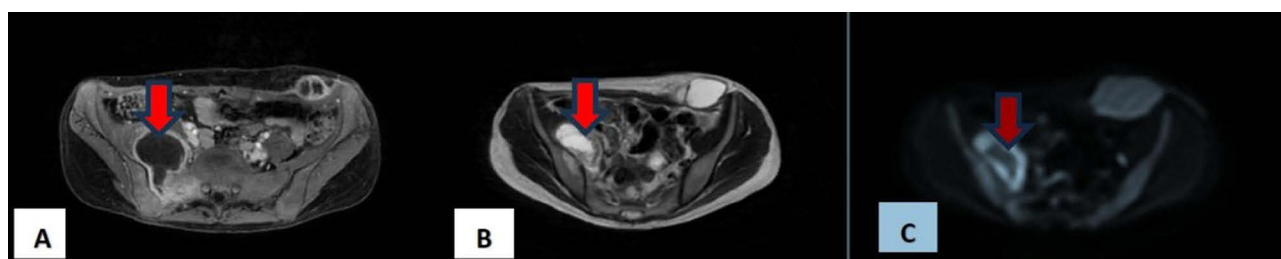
Abdominal MRI of The Right Pubic Region. Abdominal MRI demonstrated a lesion with hypointense signal on T1WI+Contrast (A, red arrow), hyperintense signal on T2WI (B, red arrow), and restricted diffusion on DWI (C, red arrow) involving the right pubic bone and pubic symphysis. The lesion was continuous with a thick-walled complex cystic lesion containing internal debris, showing rim enhancement and measured approximately $3.8 \times 10.0 \times 3.7$ cm (with an estimated volume ~17 cc) in the pelvic region. The lesion extended to involve the right obturator externus, adductor magnus, and adductor brevis muscles.
